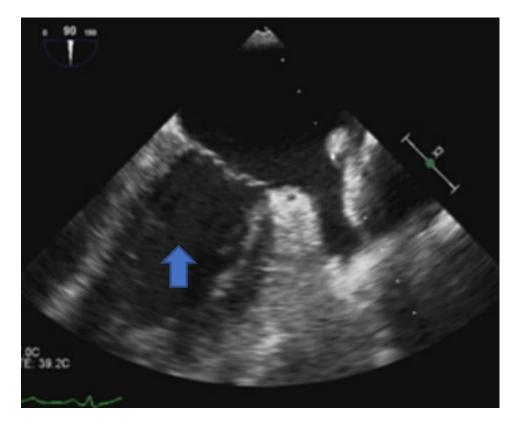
Transesophageal Echocardiogram (TEE) to 90°. Left Atrial Appendage (LAA) free of thrombi.
